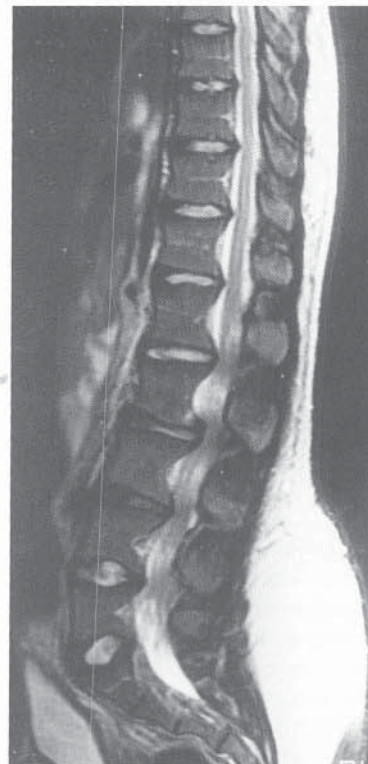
MRI of a 6-year-old girl with stenosis throughout the lumbar spine.
